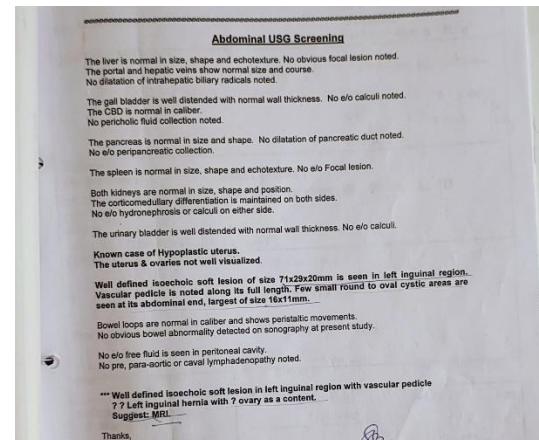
Ultrasonography of patient
